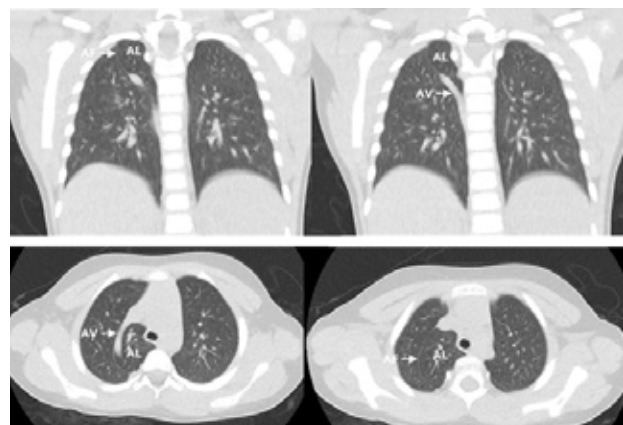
CT scan showing accessory azygos fissure (AF), azygos vein (AV) and azygos lobe (AL).
